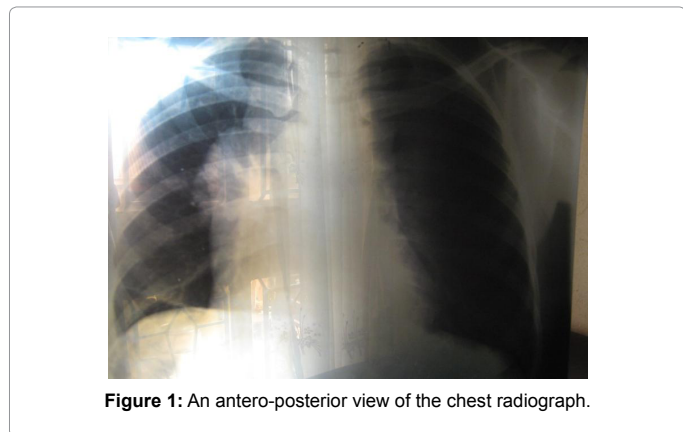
An antero-posterior view of the chest radiograph.
